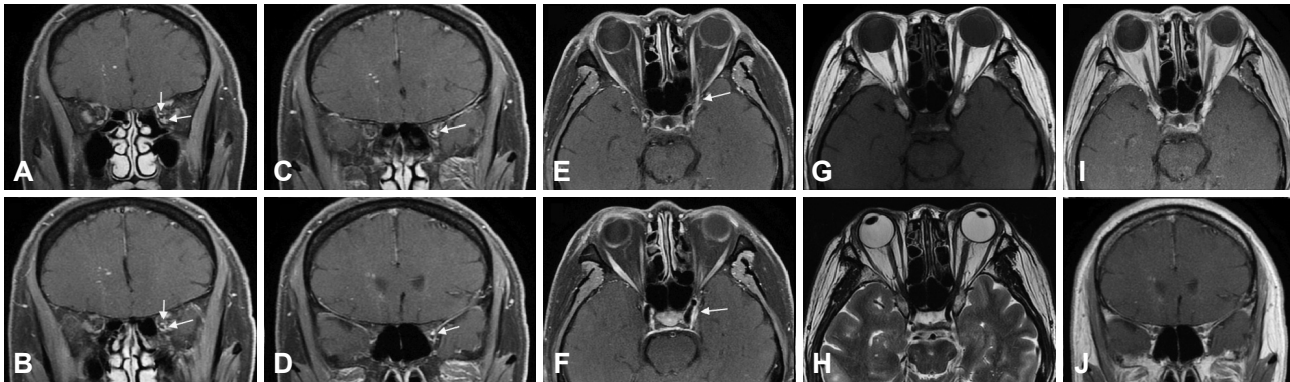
The oculomotor nerve in MRI. Enhancement of the oculomotor nerve in MRI of the cavernous sinus (A–F). The inferior branch of the oculomotor nerve with its internal rectus and inferior rectus ends was enhanced (A and B). It was difficult to find the lesion in an T1-weighted sequence (G), T2-weighted sequence (H), and contrast-enhanced sequences without fat suppression (I and J).
